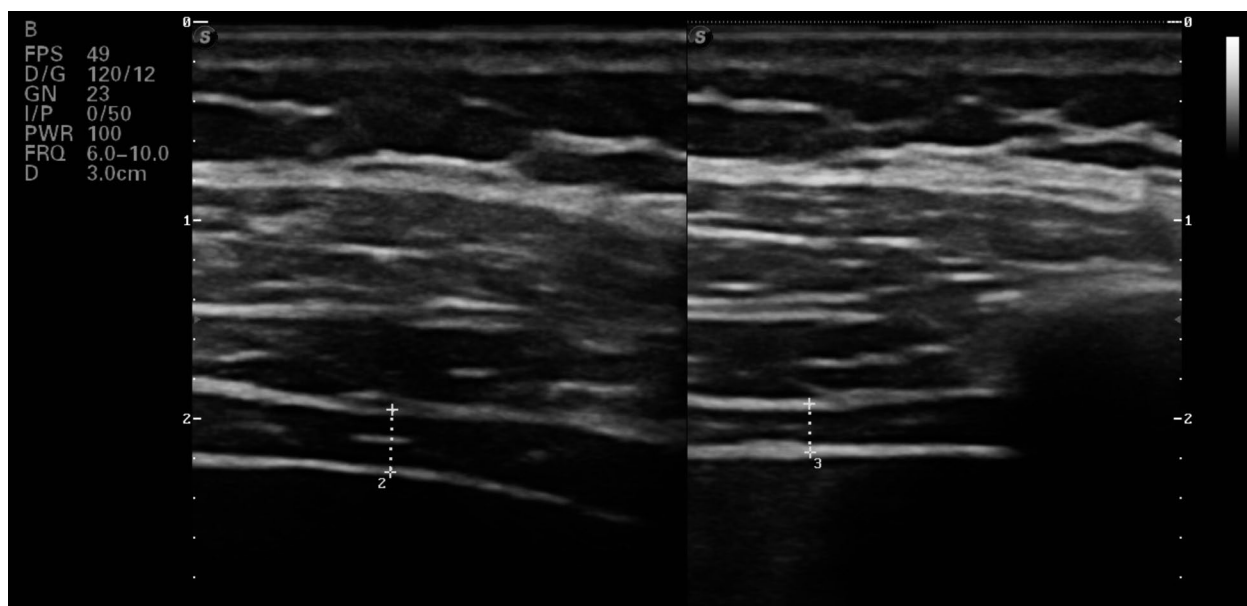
Ultrasound image of diaphragmatic thickness at: maximum inspiration (a) and maximum expiration (b)
